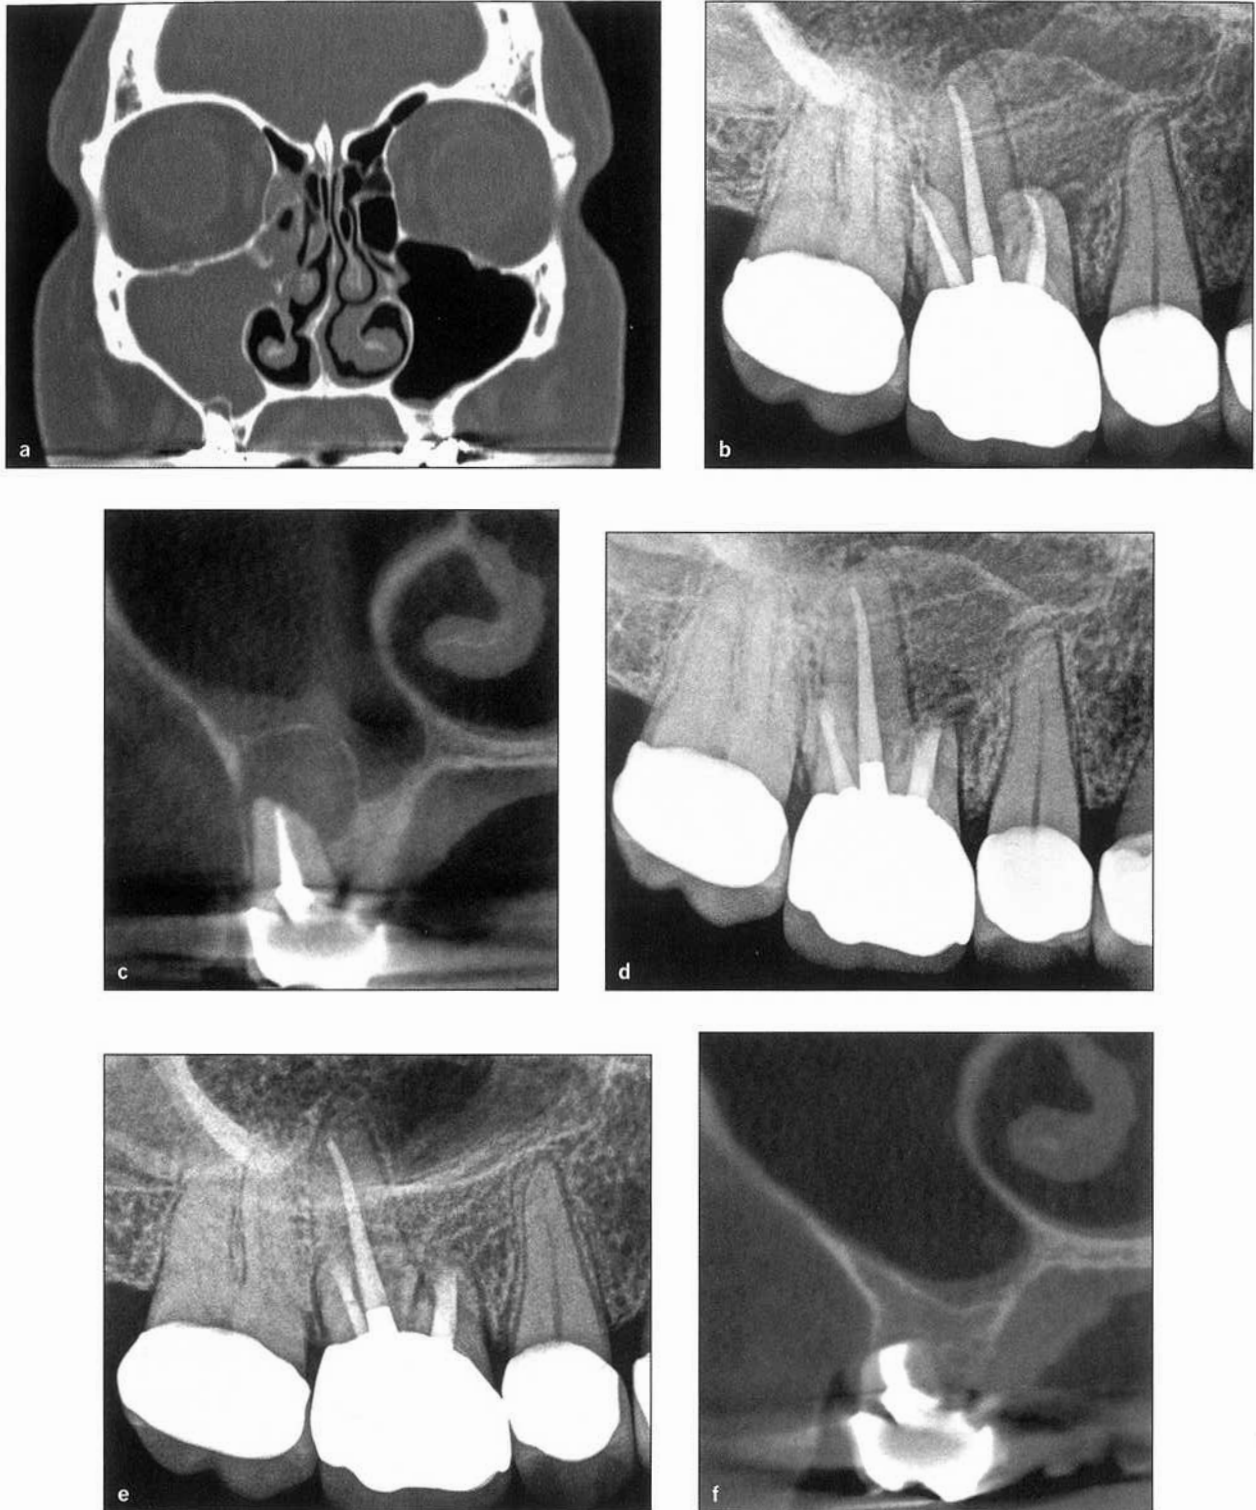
Periapical surgery of an odontogenic rhinosinusitis with a periapical osteoperiostitis lesion. (a) Sinus CT image of a fully obstructed right maxillary sinus and involvement of the right ethmoid sinuses. Medical therapies had failed, and endoscopic sinus surgery was planned. Note the osteoperiostitis lesion in the floor of the right maxillary sinus suggestive of an odontogenic source. (b) Periapical radiograph of a failing endodontic treatment despite the apparently well-filled canal system. (c) Coronal CBCT image of the osteoperiostitis lesion in the floor of the right maxillary sinus. (d) Postoperative periapical radiograph of the endodontic surgery. (e) One-year recall radiograph following periapical surgery shows evident healing. (f) Coronal CBCT image at the 1-year postsurgical follow-up showing full resolution of the buccal osteotomy, cortical sinus floor, periapical osteoperiostitis lesion, and odontogenic rhinosinusitis. The patient's rhinosinusitis symptoms resolved completely, and the planned sinus surgery was not performed.
